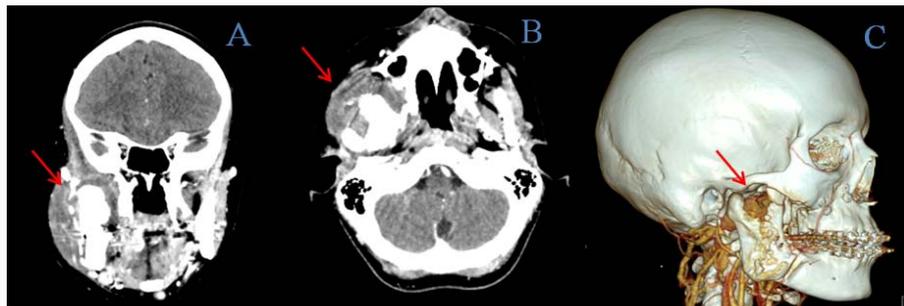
CT scan with contrast: A, coronal view, B axial views and C, 3 dimensions reconstruction revealed a well-defined radiolucent cavity (arrow), involving the medial and part of the lateral aspect of the right mandibular ramus, near the sigmoid notch.
